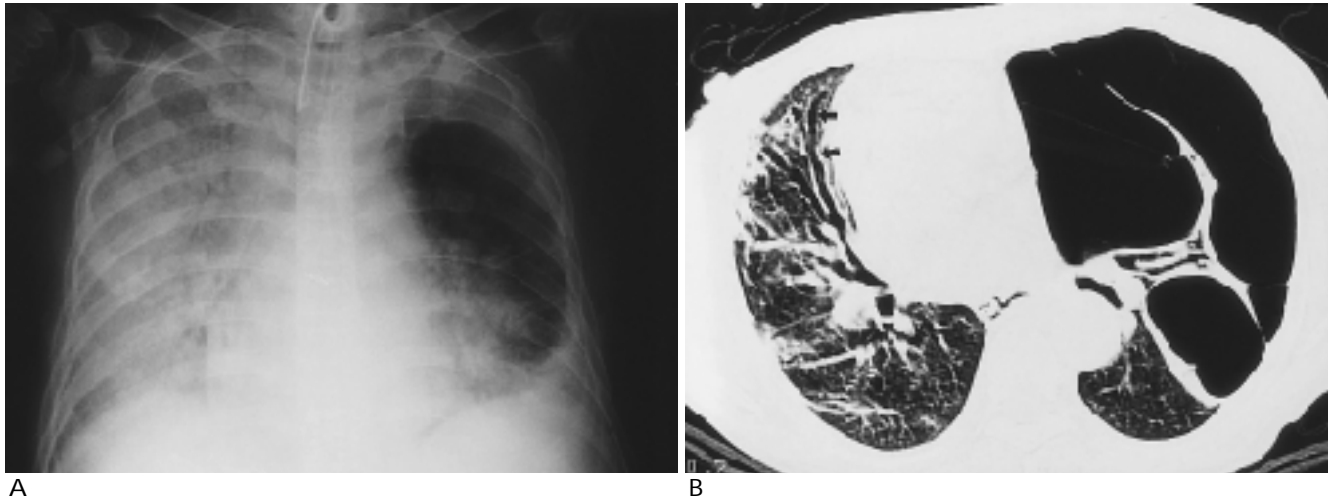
A. Chest radiograph (onset of ARDS) shows total haziness with air-bronchograms in the right lung and ill-defined haziness in the left lung.
